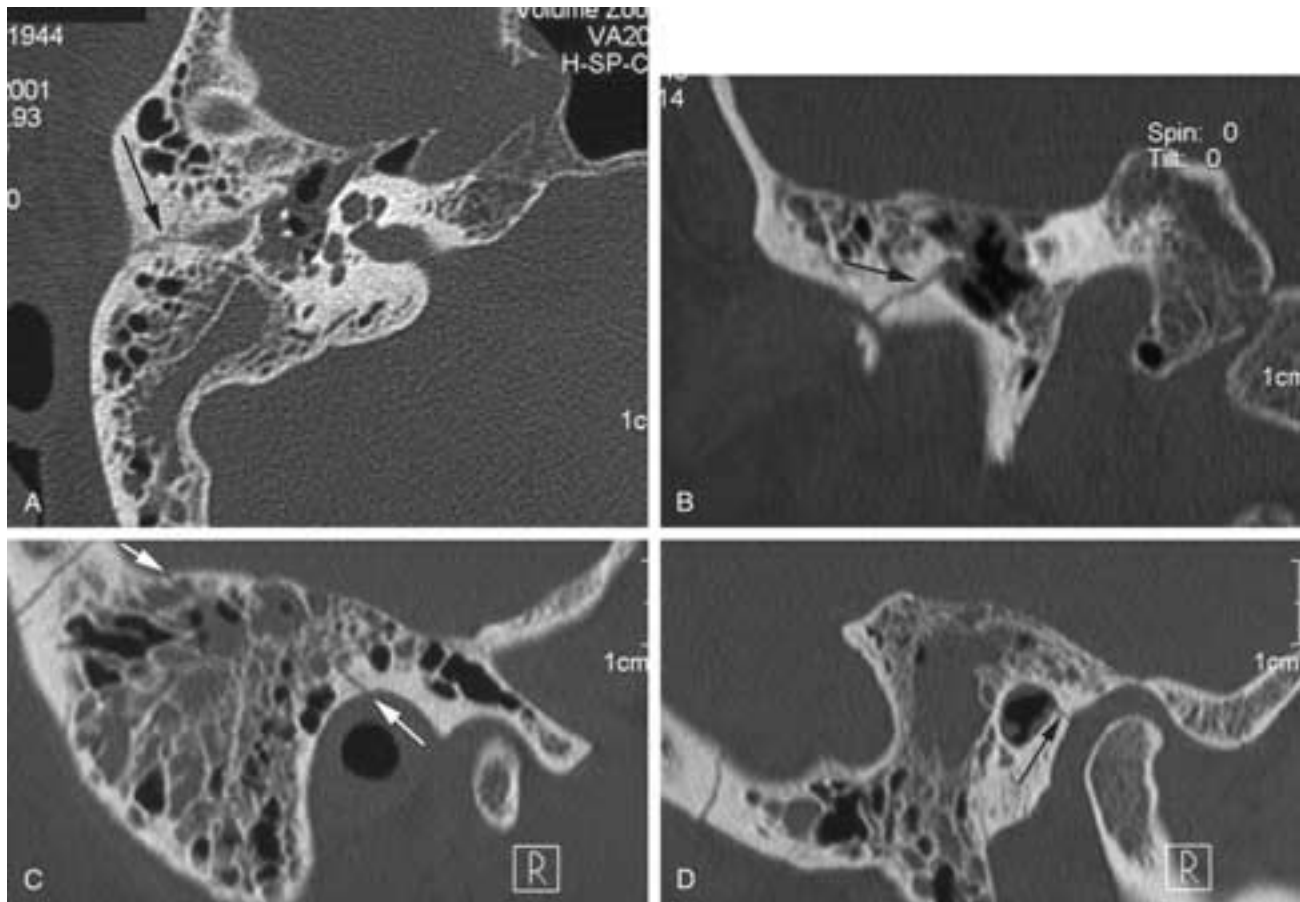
Longitudinal fracture with multidetector CT and multiplanar reformatting. A, Axial plane. The fracture (*arrow*) is oblique to this plane but is seen passing along the roof of the EAC. There is fluid (blood) in the mastoid and middle ear. B, Coronal reformat shows the fracture (*arrow*) extending into the middle ear. C, Sagittal plane reformat is perpendicular to the fracture line and shows the fracture crossing the tegmen and extending into the external canal (*arrows*). D, Sagittal reformat medial to C shows fracture (*arrow*) extending into the temporomandibular joint.
